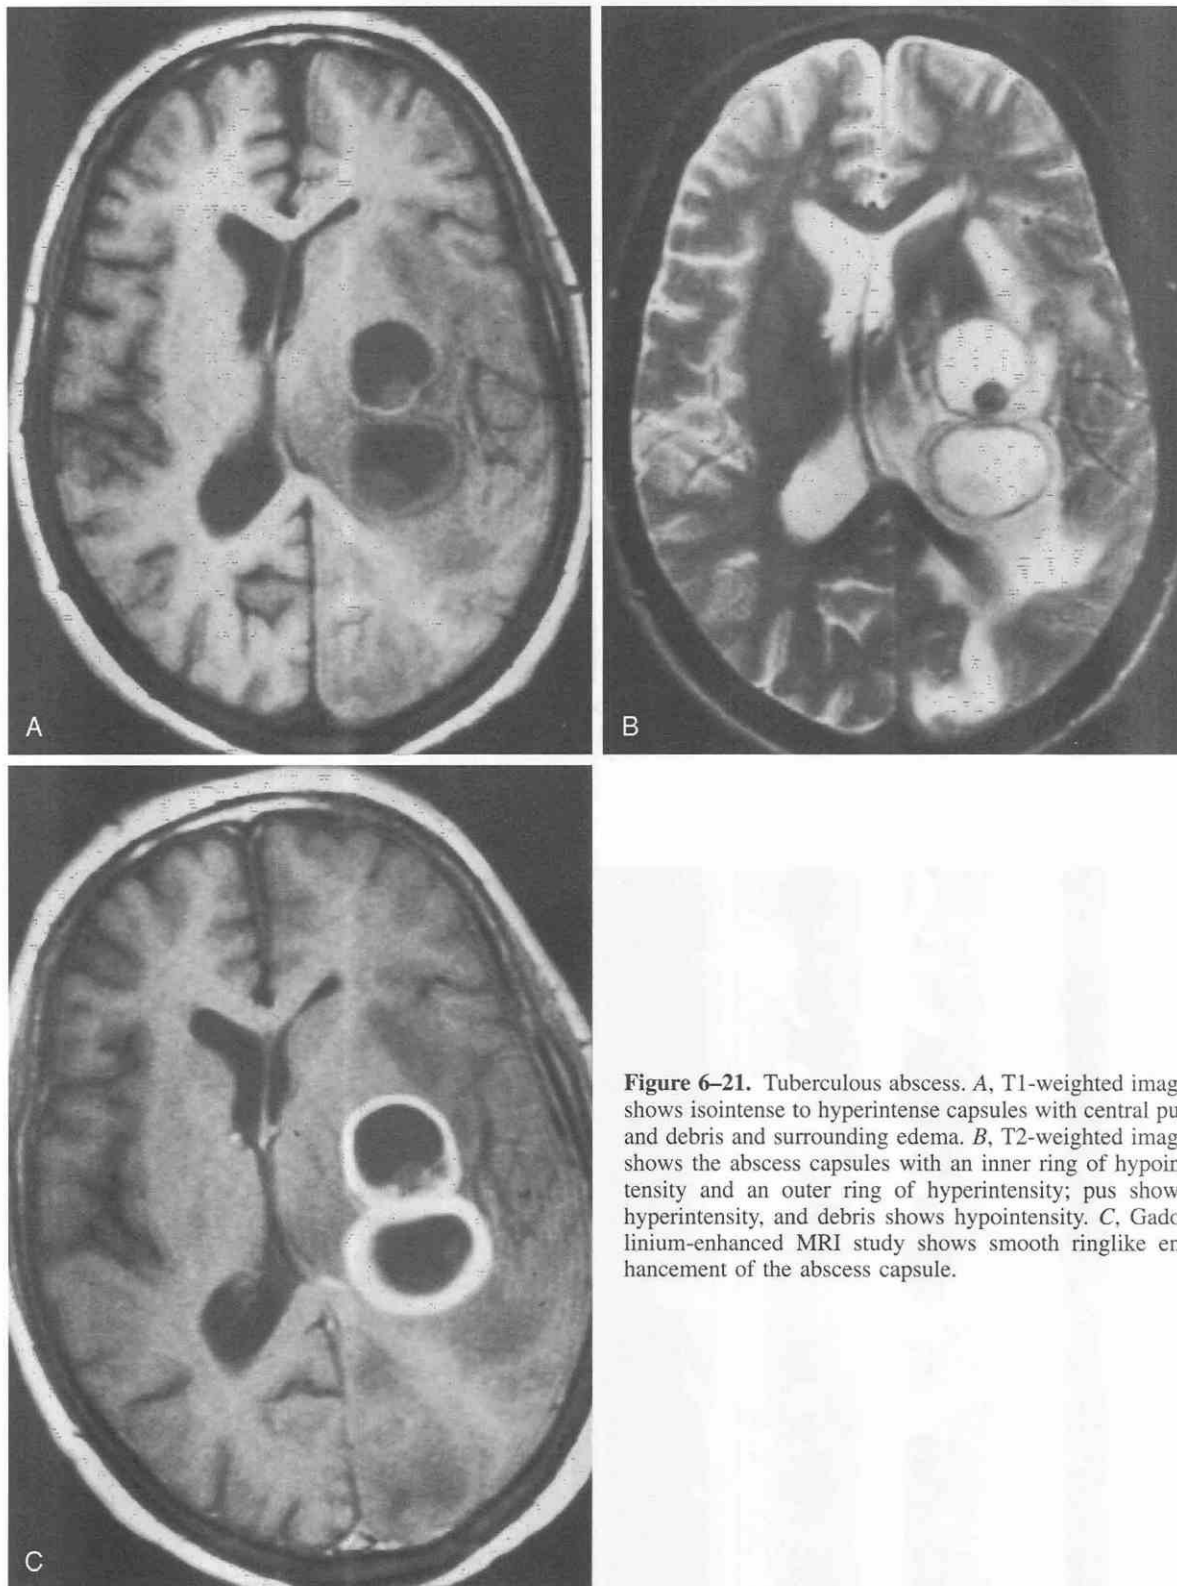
Tuberculous abscess. *A*, T1-weighted image shows isointense to hyperintense capsules with central pus and debris and surrounding edema. *B*, T2-weighted image shows the abscess capsules with an inner ring of hypointensity and an outer ring of hyperintensity; pus shows hyperintensity, and debris shows hypointensity. *C*, Gadolinium-enhanced MRI study shows smooth ringlike enhancement of the abscess capsule.
